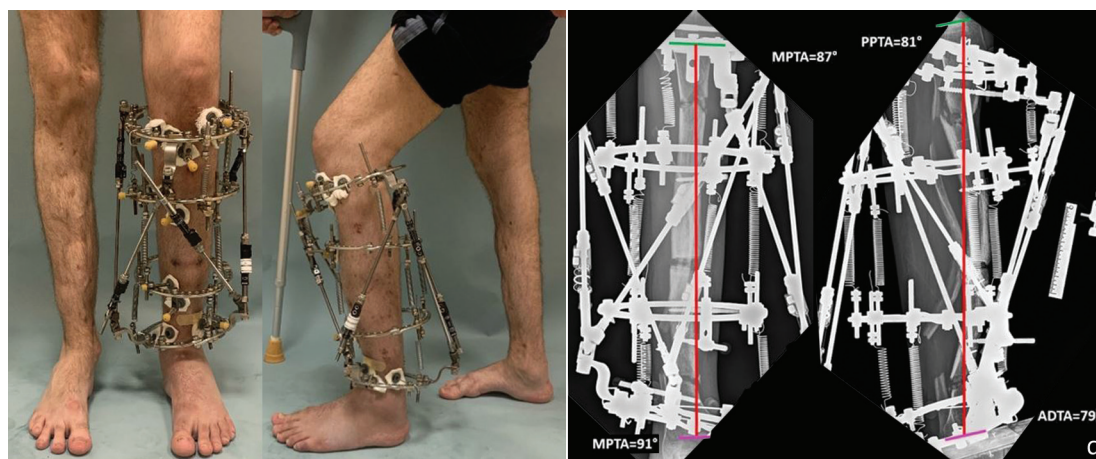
(continued) Clinical case of applying the "spring" technique for tri-apical deformity of the tibia: (d) photo of the patient and his radiographs at the end of the correction
